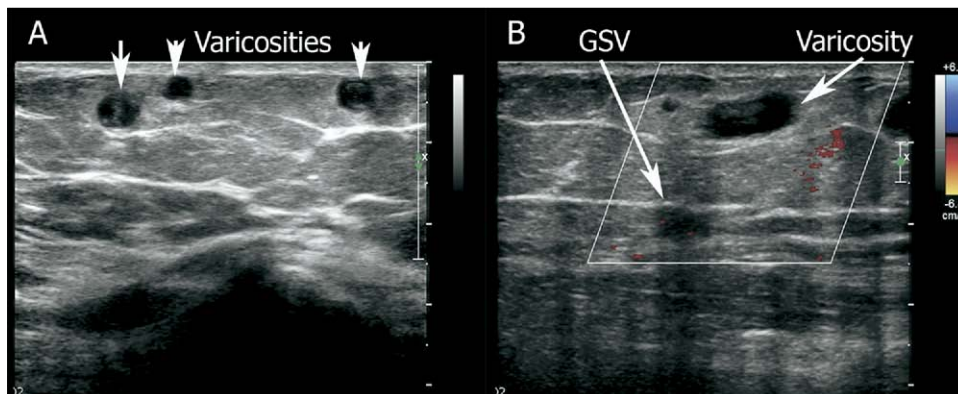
(A) Grayscale US that shows superficial varicosities after treatment with foam sclerosis. The vein has a thickened wall. (B) Color Doppler US that shows no flow in the GSV (treated by ELA) nor in the varicosity (treated by foam sclerosis).
